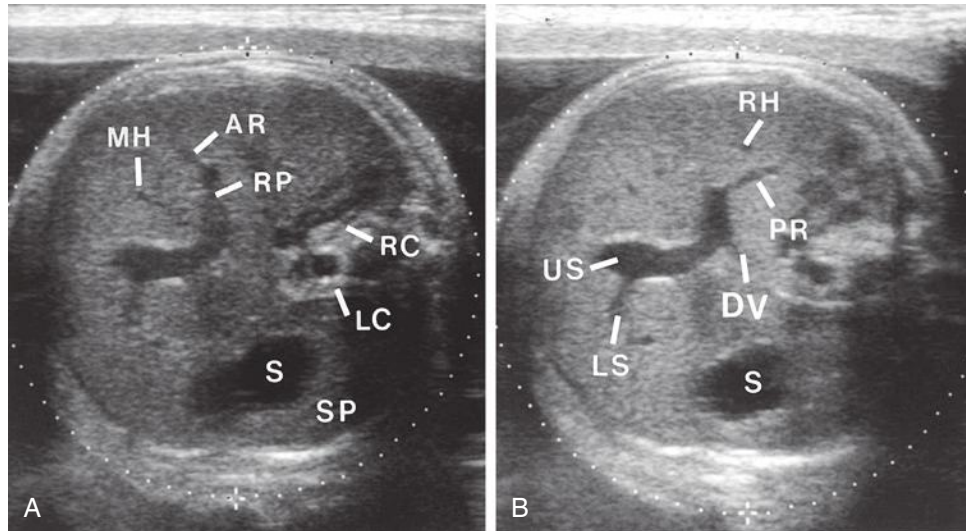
A and B, Transverse axial sonograms of fetal liver. AR, anterior division of right portal vein; DV, ductus venosus (alternatively, this may represent a partial section through the main portal vein—see Fig. 8-72B); LC, left diaphragmatic crura; LS, lateral segmental branch; MH, middle hepatic vein; PR, posterior division of right portal vein; RC, right diaphragmatic crura; RH, right hepatic vein; RP, right portal vein; S, stomach; SP, spleen; US, umbilical segment of left portal vein.
